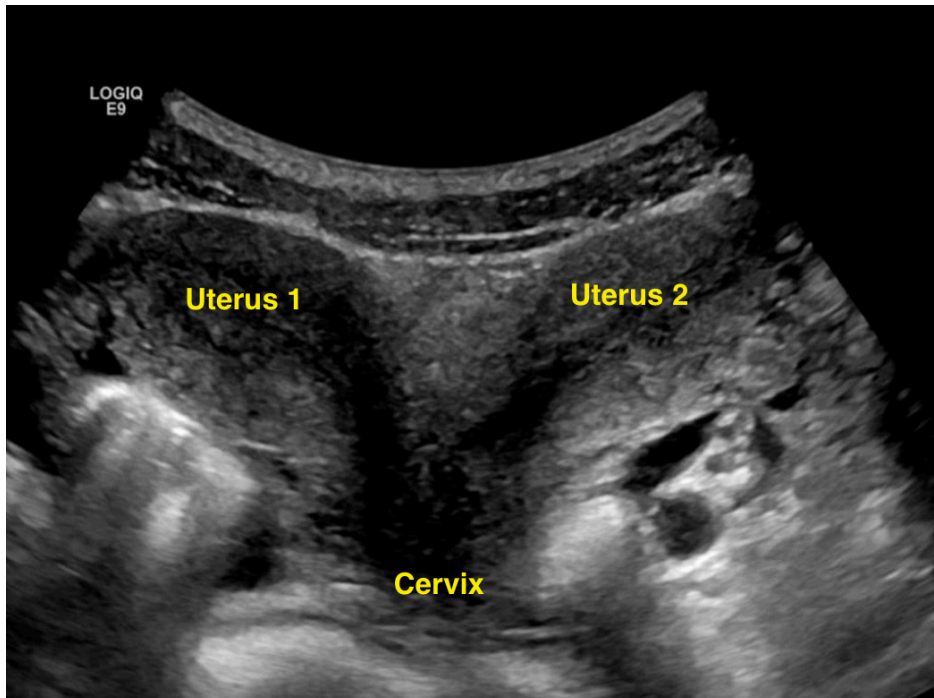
Ultrasound Examination before Pregnancy Shows 2 Uterus
